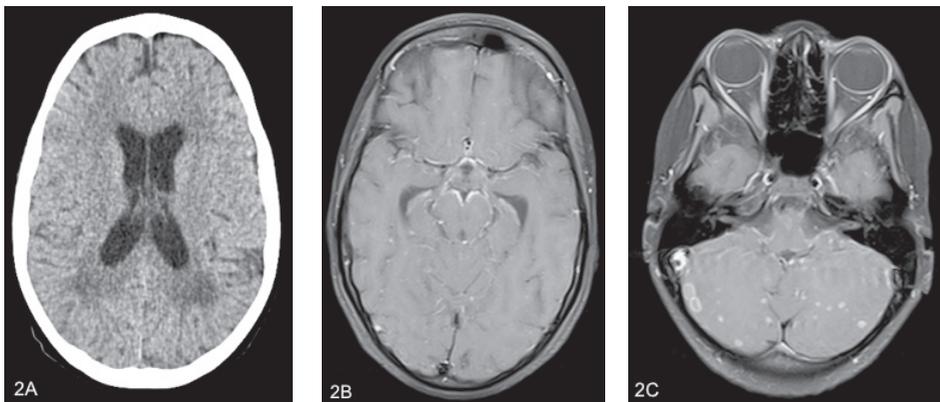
Computed tomography of a 13-year old child presenting with disseminated TB and loss of consciousness. The initial CT only revealed bilateral periventricular hypodensities and hydrocephalus. Figure 2B-C. T1-weighted post-gadolinium MRI 2 days later revealed basal meningeal enhancement and multiple ring-enhancing lesions (miliary nodules) in the cerebellar hemispheres.
